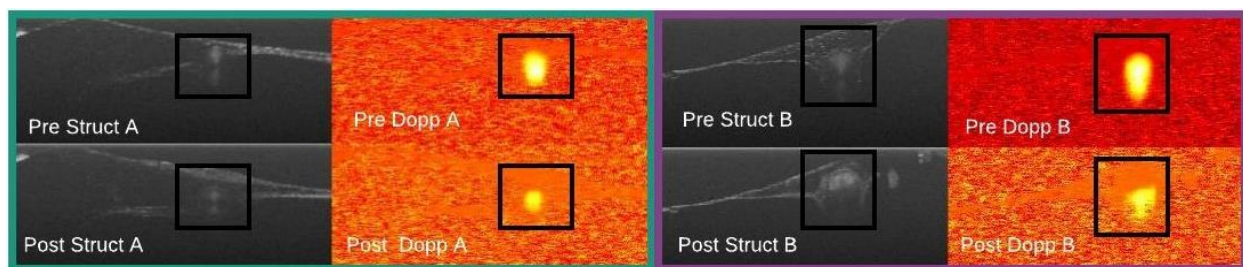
Vessel constriction (A, green rectangle) and partial embolism (B, purple rectangle), markers indicating a partial seal. Black boxes indicate the ROI's. In data point A, the Doppler signal area has clearly been reduced by more than 15% while vessel constriction is apparent from the change in vessel diameter from pre to post structural images. In data point B, the Doppler signal area has decreased by more than 15% while from the post structural image, the homogenous signal coming from the superficial portion of the vessel lumen indicates that partial embolism has been achieved.
